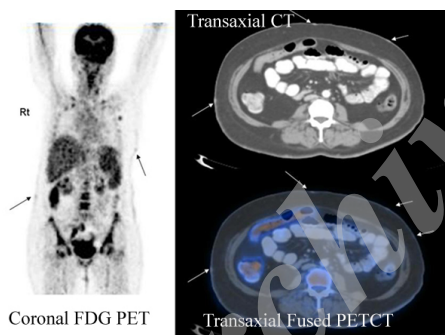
¹⁸F-FDG PETCT images show minimally increased FDG uptake in multiple enhancing thoracic and abdominal skin nodules (SUV Max 1.5). Splenomegaly present with no increased FDG uptake.
